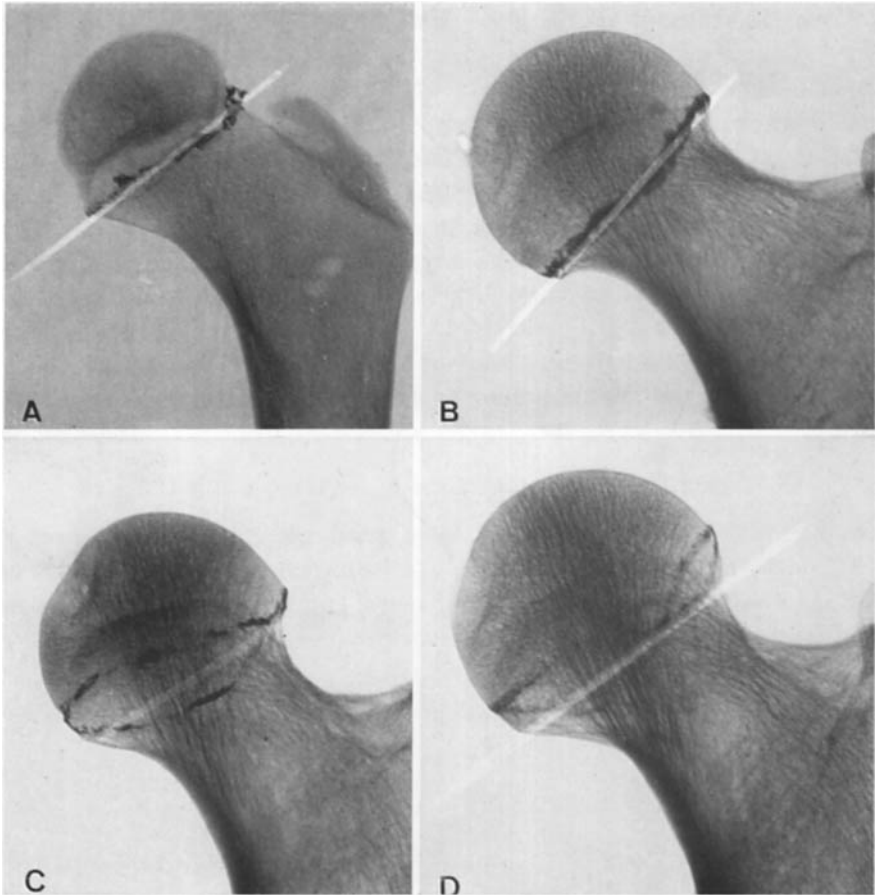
Edge of joint surface and baseline. X-ray film of bones on which the edge of the joint surface of the femoral head is marked by a contrasting paint. The baseline is drawn on the X-ray film as stated in the text (1 child (A), 3 adults). The baseline cannot be traced with as much accuracy in adults as in children, since in adults the epiphyseal line is visible only as an indistinct trace in the bone. As a rule, it is drawn too far distally (d), because during puberty the edges of the epiphyses are prolonged distally.
